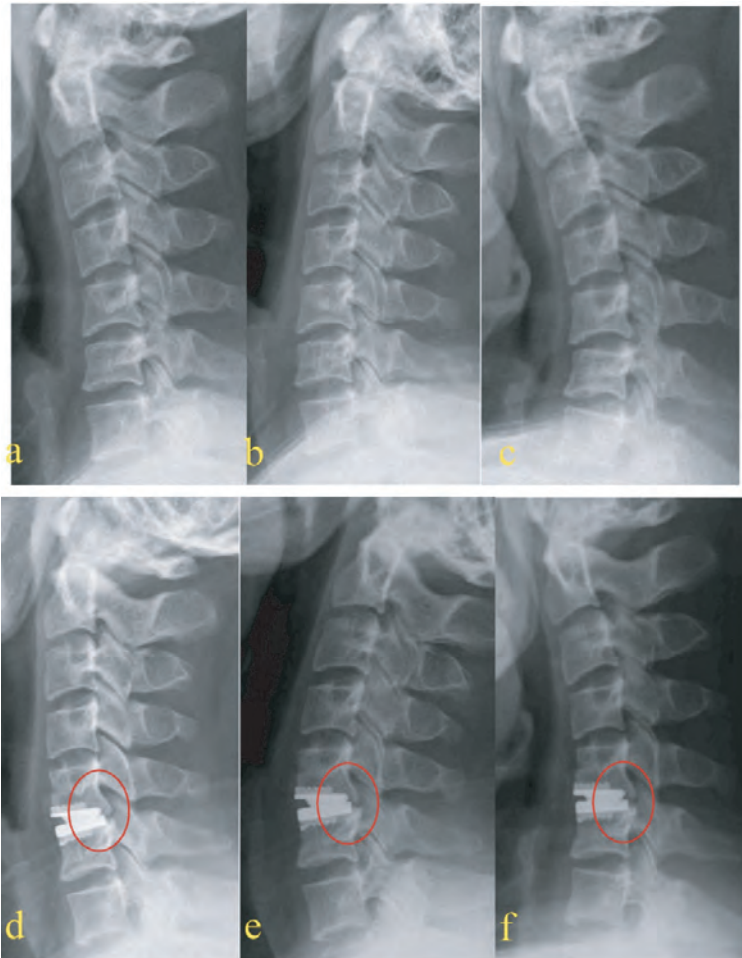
Case presentation. a, b, c: preoperative neutral, extension and flexion X-rays; d, e, f: neutral, extension and flexion X-rays at 5-year follow-up; red circle indicated the grade III HO foramion.
